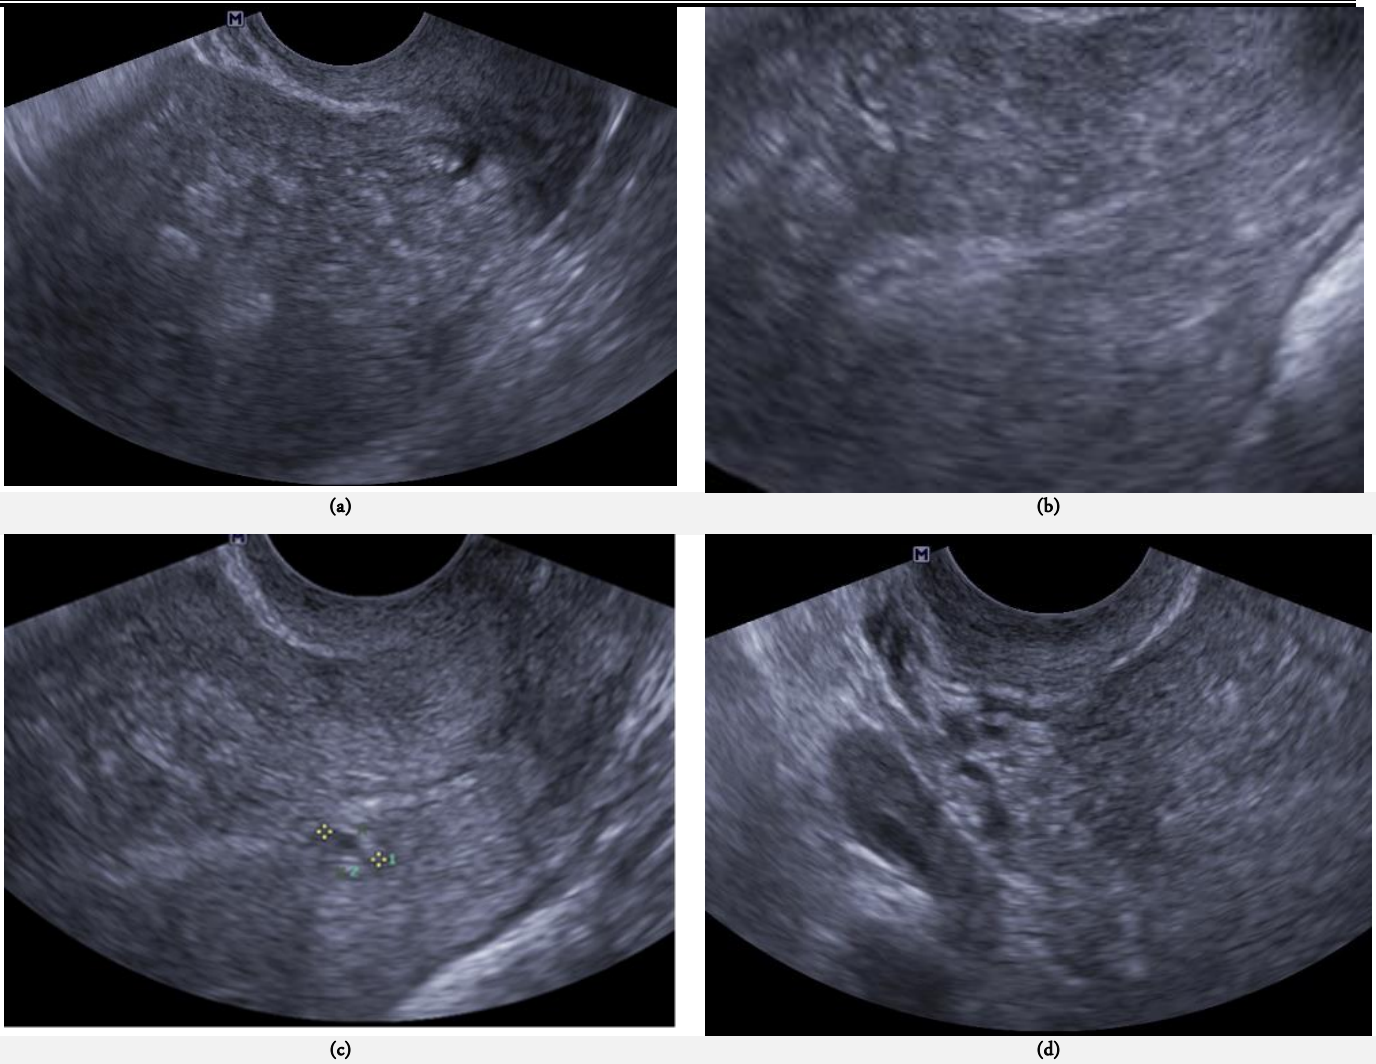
presented ultrasound of female patient, 55 years old. The TVUS showed (a) myometrial inhomogeneous echopattern with multiple tiny hyperechoic foci seen distributed diffusely within myometrium, (b) Interrupted transional (junctional) zone, (c) focal adenomyoma, (d) small size (atrophied) ovary with no focal lesions.
